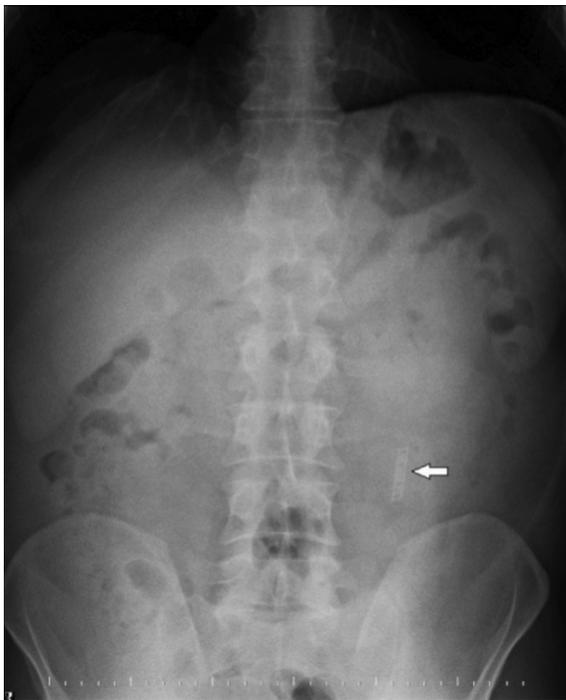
Image of a foreign body in the direct abdominal X-ray
